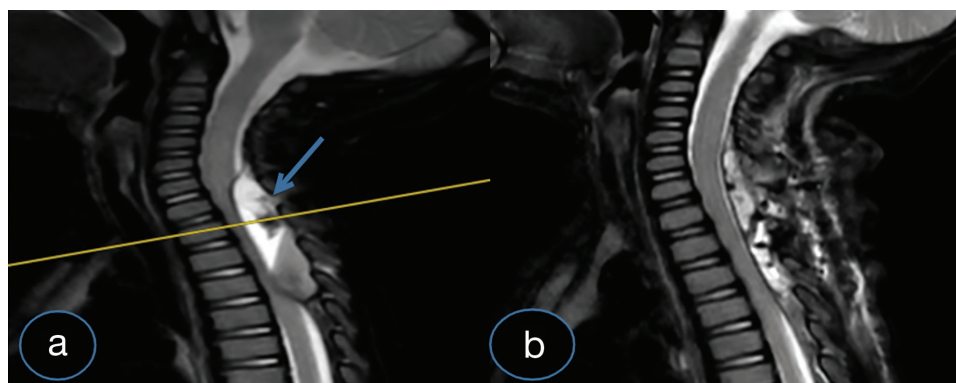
(a) Sagittal T2 weighted images using magnetic resonance imaging (MRI) revealing a dorsal epidural lesion at C6–Th3 pre-operatively. See blue arrow and yellow line. (b) A post-operative MRI scan showing no evidence of residual vascular malformations 10 months post-surgery.
